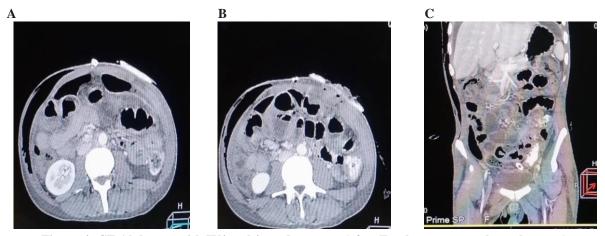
CT Abdomen with IV/ oral /rectal contrast (after Exp laporatomy + loop clostomy)
